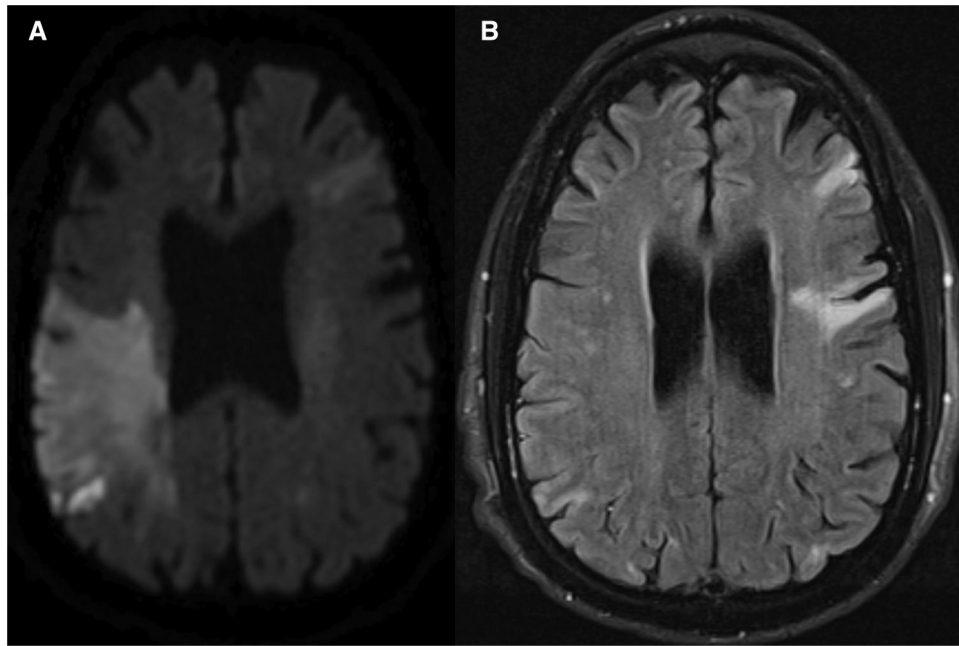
Axial (A) DWI images demonstrate a large right MCA territory area of restricted diffusion. This occupies approximately half of the MCA territory. There is an additional small area of restricted diffusion in the left frontal lobe. (B) FLAIR MR images demonstrate minimal areas of hyperintensity in the right MCA territory. There are areas of FLAIR hyperintensity on the left. Given DWI-FLAIR mismatch, intravenous tPA was administered.
